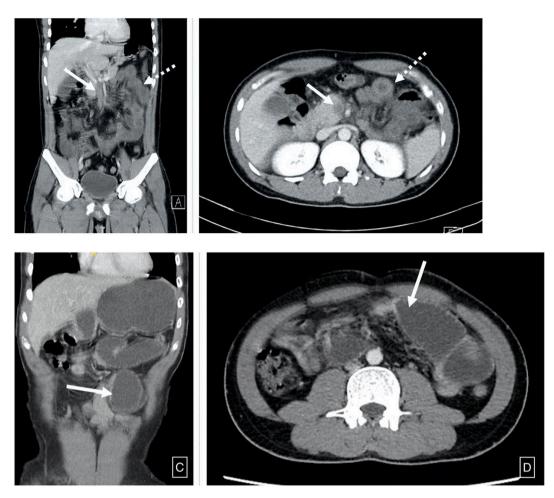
A computed tomography scan of the abdomen and pelvis revealed A, B: Superior mesenteric vein thrombosis (bold arrow) and diffuse mural thickening (dotted arrow), C, D: High grade small bowel obstruction with a transition point (bold arrow) seen in mid jejunum. Images obtained from Pang et al.²⁸ Annals of Vascular Surgery available online on August 28, 2020, (copyright 2020), and permission to use granted by Elsevier and Copyright Clearance Center.
